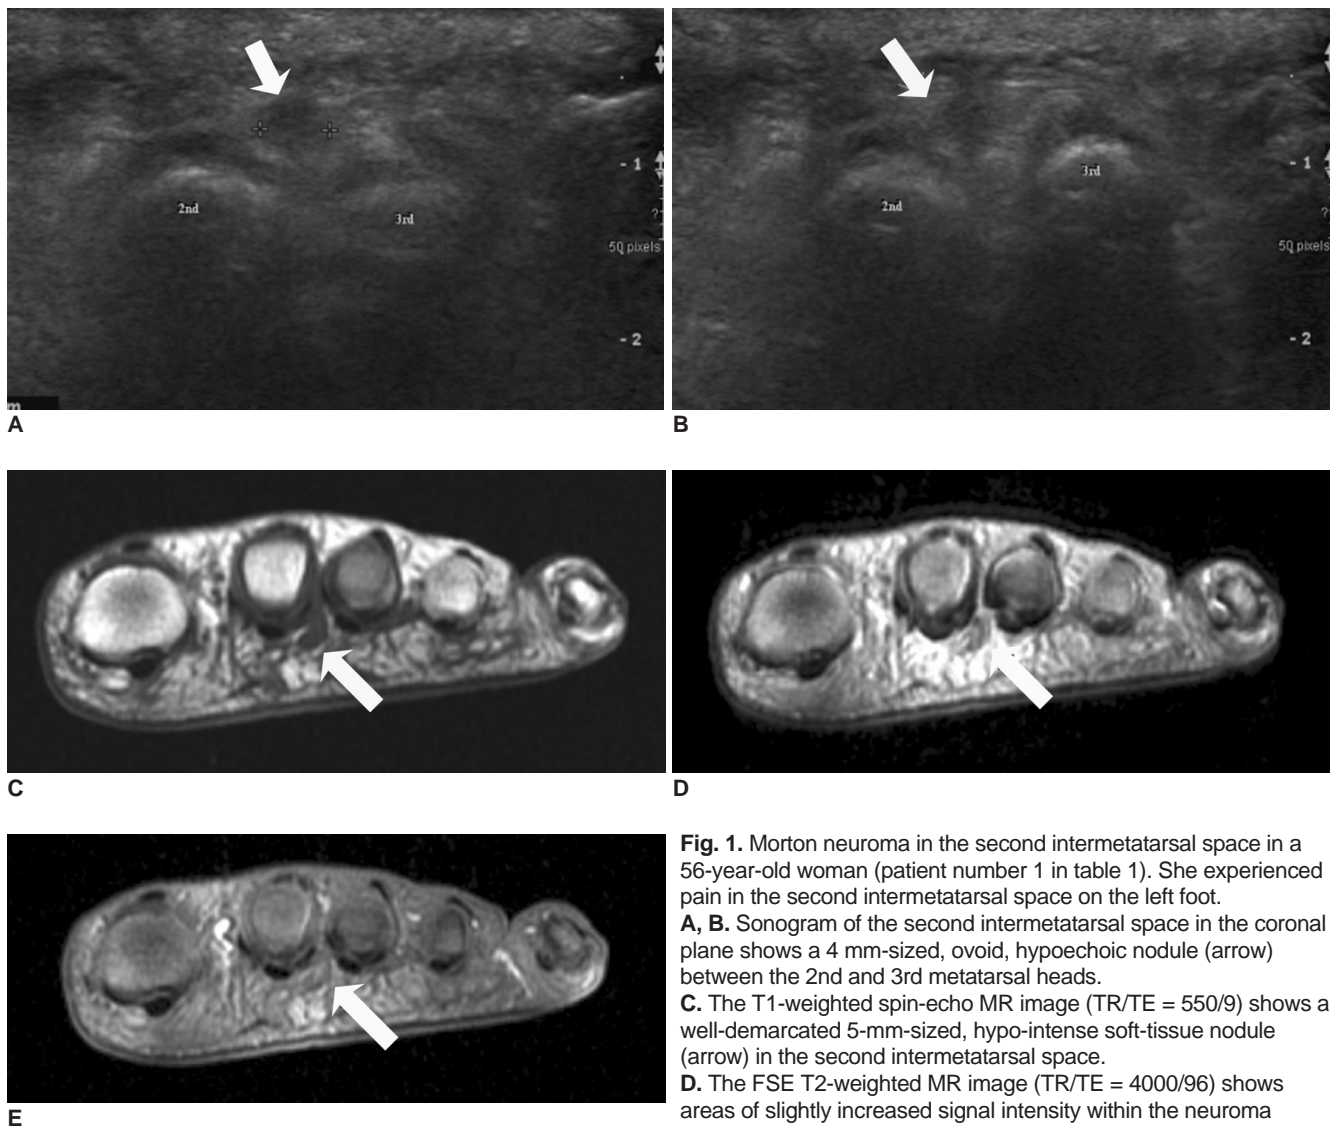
Morton neuroma in the second intermetatarsal space in a 56-year-old woman (patient number 1 in table 1). She experienced pain in the second intermetatarsal space on the left foot. A, B. Sonogram of the second intermetatarsal space in the coronal plane shows a 4 mm-sized, ovoid, hypoechoic nodule (arrow) between the 2nd and 3rd metatarsal heads. C. The T1-weighted spin-echo MR image (TR/TE = 550/9) shows a well-demarcated 5-mm-sized, hypo-intense soft-tissue nodule (arrow) in the second intermetatarsal space. D. The FSE T2-weighted MR image (TR/TE = 4000/96) shows areas of slightly increased signal intensity within the neuroma (arrow). E. The T1-weighted fat-suppressed contrast-enhanced spin-echo MR image (TR/TE = 617/12) shows mild enhancement in the nodule (arrow).
